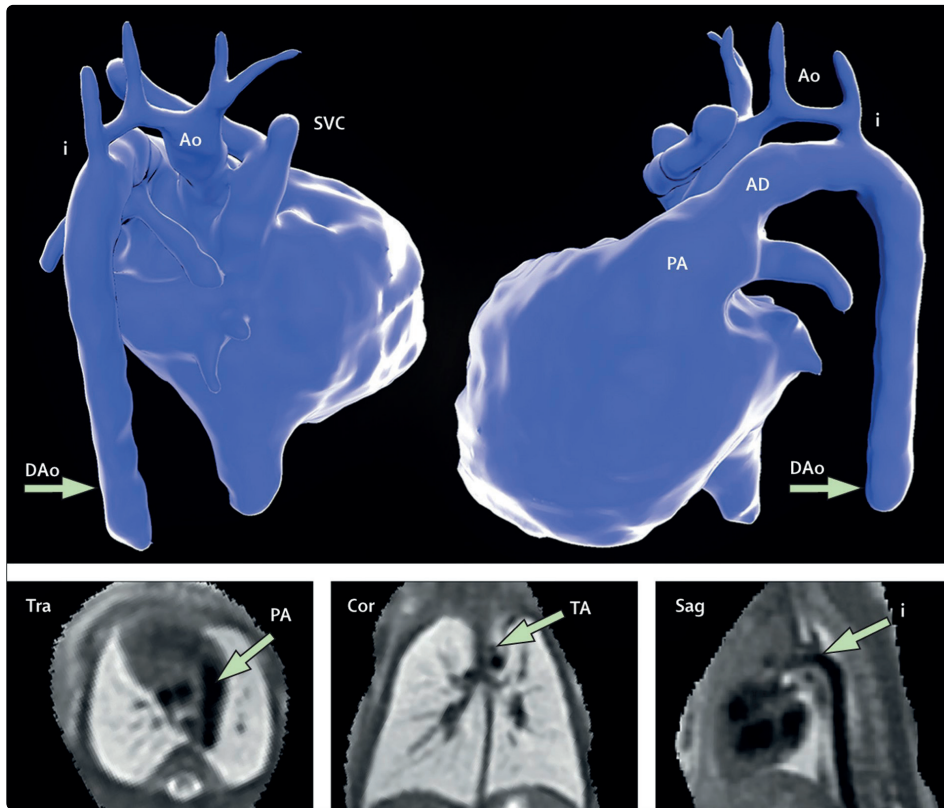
Segmentation of motion-corrected MRI data of a fetus with suspected coarctation of the aorta at 33 weeks' gestation. Posterior projection (top left) and left lateral projection (top right) are shown. The aorta (Ao), arterial duct (AD), descending aorta (DAo), aortic isthmus (i), and superior vena cava (SVC) are labelled. Coarctation was confirmed after birth and treated surgically. The bottom panel shows planes from the reconstructed 3D dataset in a transverse (Tra), coronal (Cor), and sagittal (Sag) orientation. See video 2 for more detail. TA=transverse arch. PA=pulmonary artery. Figure from Lloyd et al.¹¹
